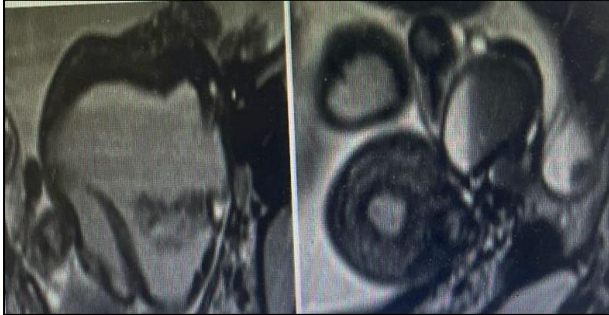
MRI pelvis picture.
